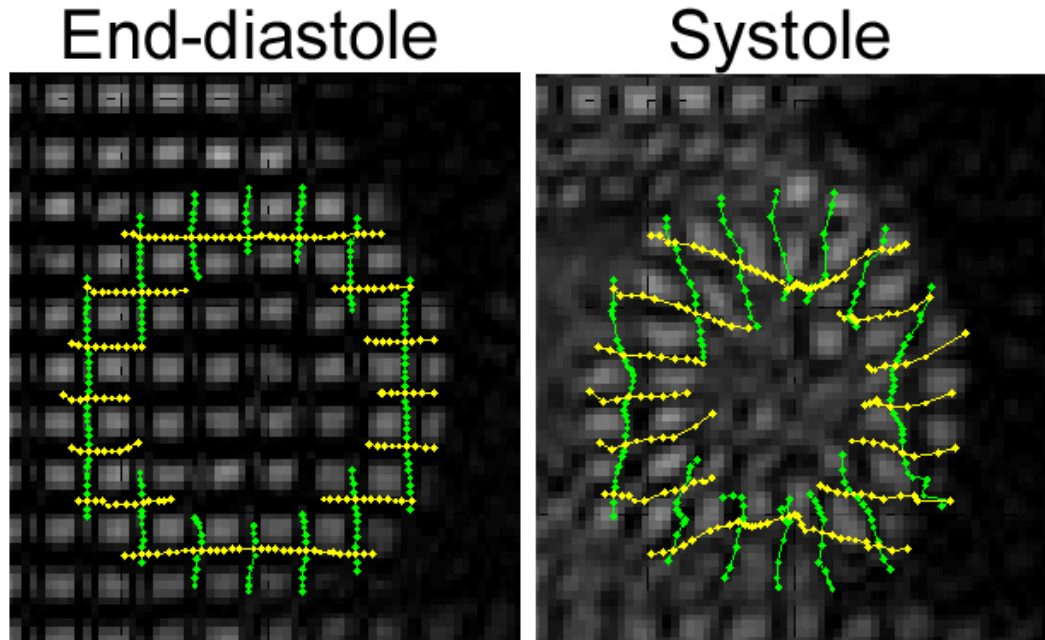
Computed trajectories superimposed onto tagged MRI images.*
